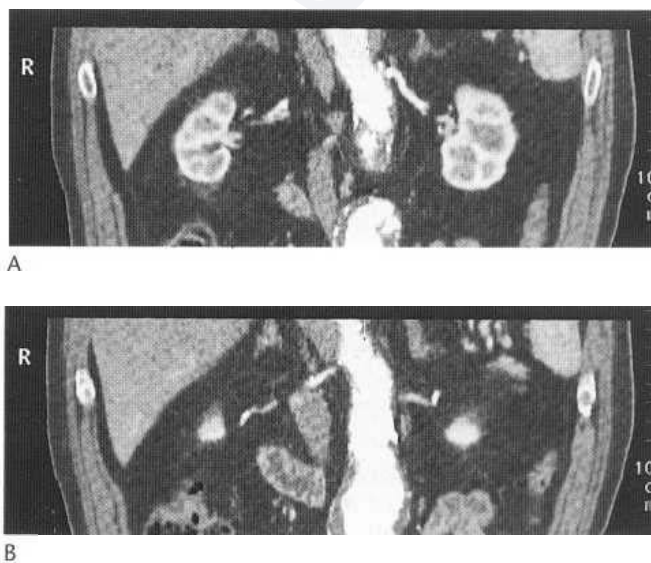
CT angiogram (coronal reconstruction). A tight stenosis of the origin of the right renal artery is demonstrated.
